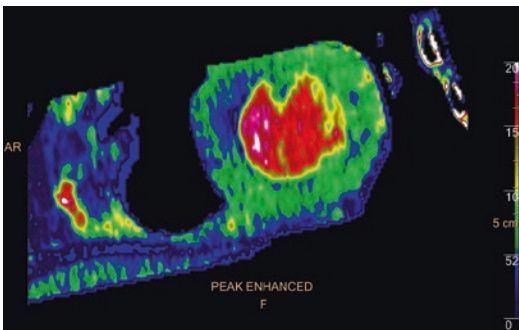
A color-map representation of a short-axis image from a dynamic myocardial perfusion CT scan showing regions with low enhancement in the inter-ventricular septum (in blue) caused by a lesion in the mid-LAD (Image courtesy of: Drs. Armin Huber, Daniela Muenzel and Bettina Gramer, Klinikum rechts der Isar der Technischen, Universität München, Munich, Germany)
